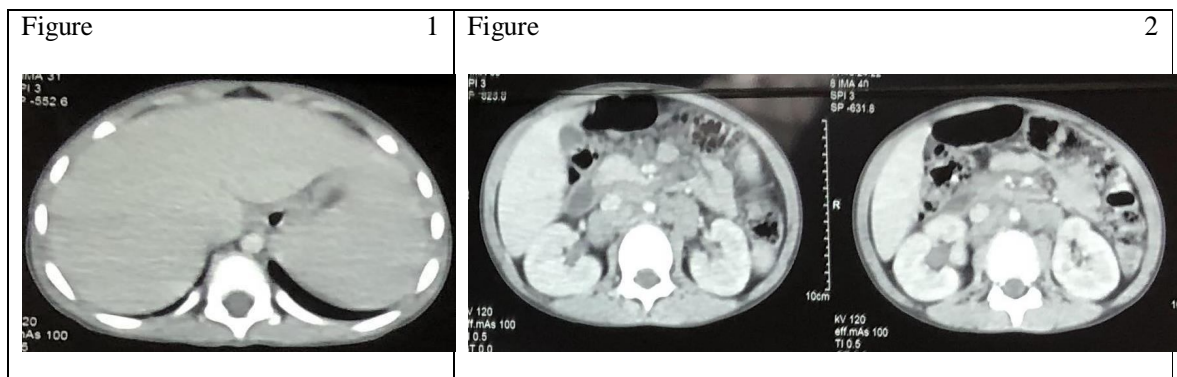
The cervico-thoraco-abdominal CT scan; homogeneous hepatosplenomegaly and lymphadenopathy.
